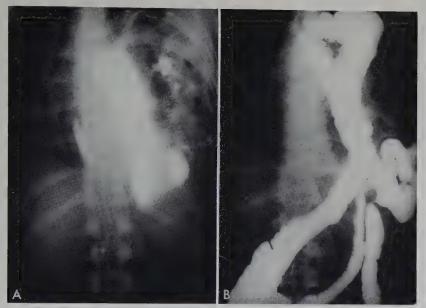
Roentgenograms of patient with rupture of left diaphragm. A. Displacement of stomach into left pleural space. B. Large segment of the colon also in the left pleural space.
